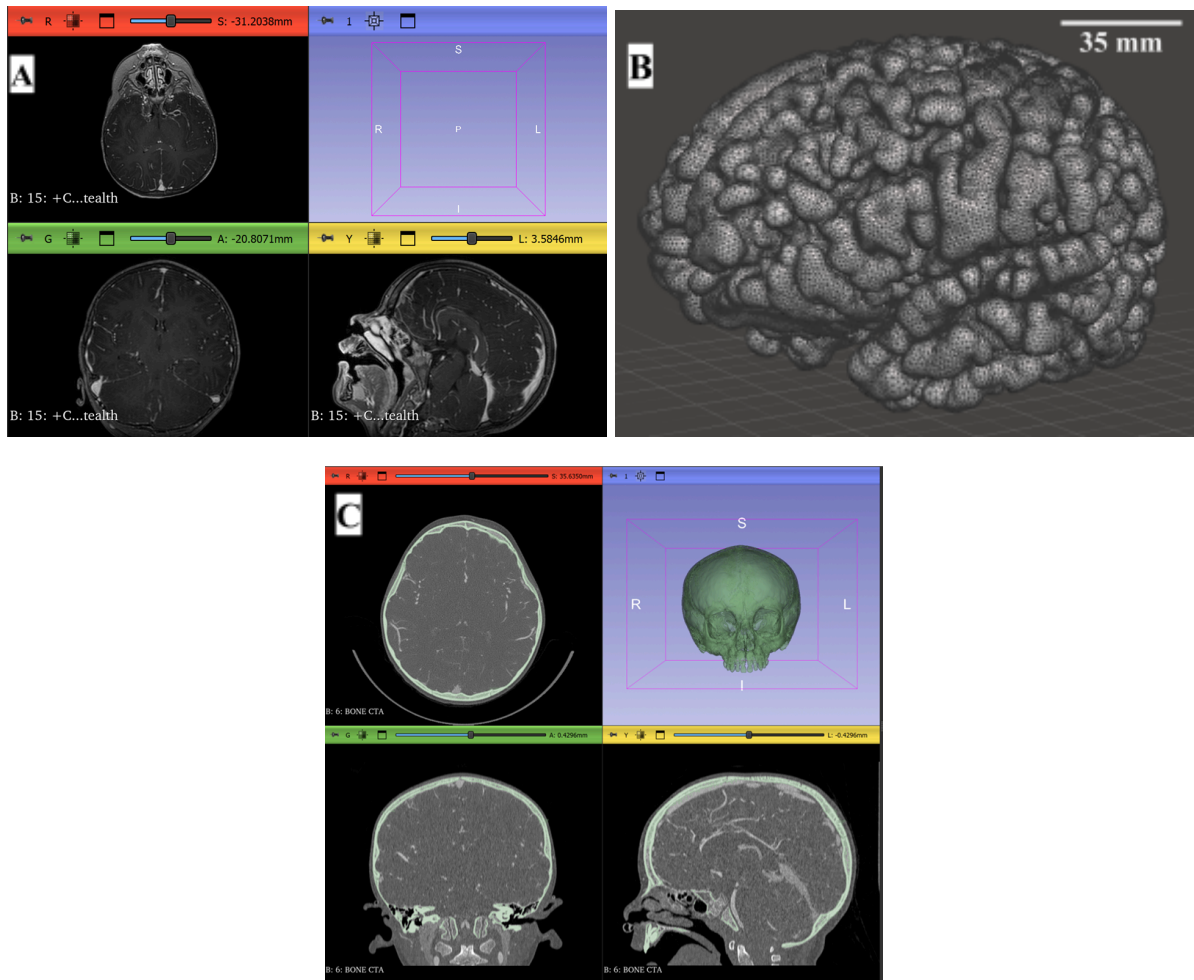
(A) Anonymized MRI scan of a 5-7 year old patient DICOM data in 3D Slicer prior to segmenting T1-weighted MR images and exporting into SimNIBS. (B) 3D model of brain
